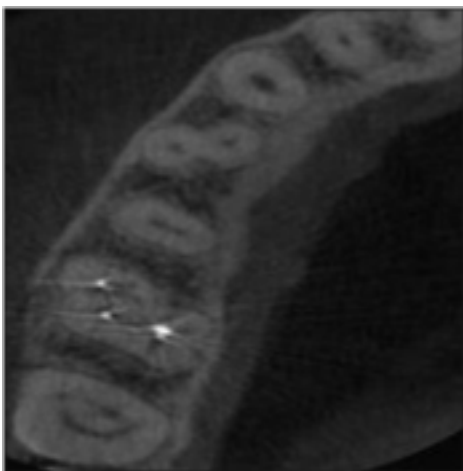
Cbct Image Showing 6 Separate Canals
